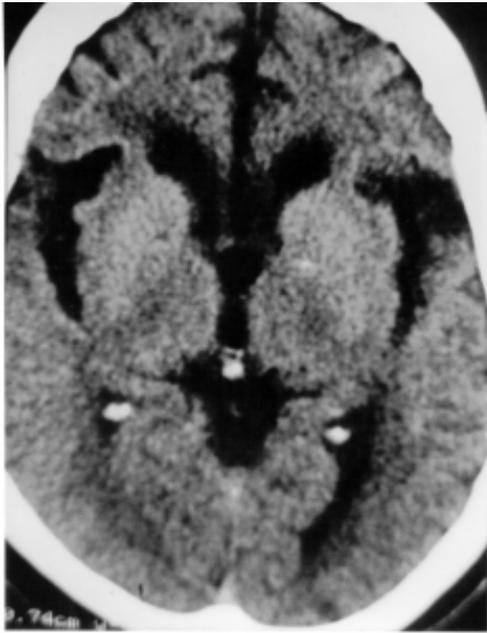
CT scan without contrast, showing moderate diffuse cortical atrophy and moderate dilatation of the ventricular system, in a 63-year-old woman with moderate AD.
